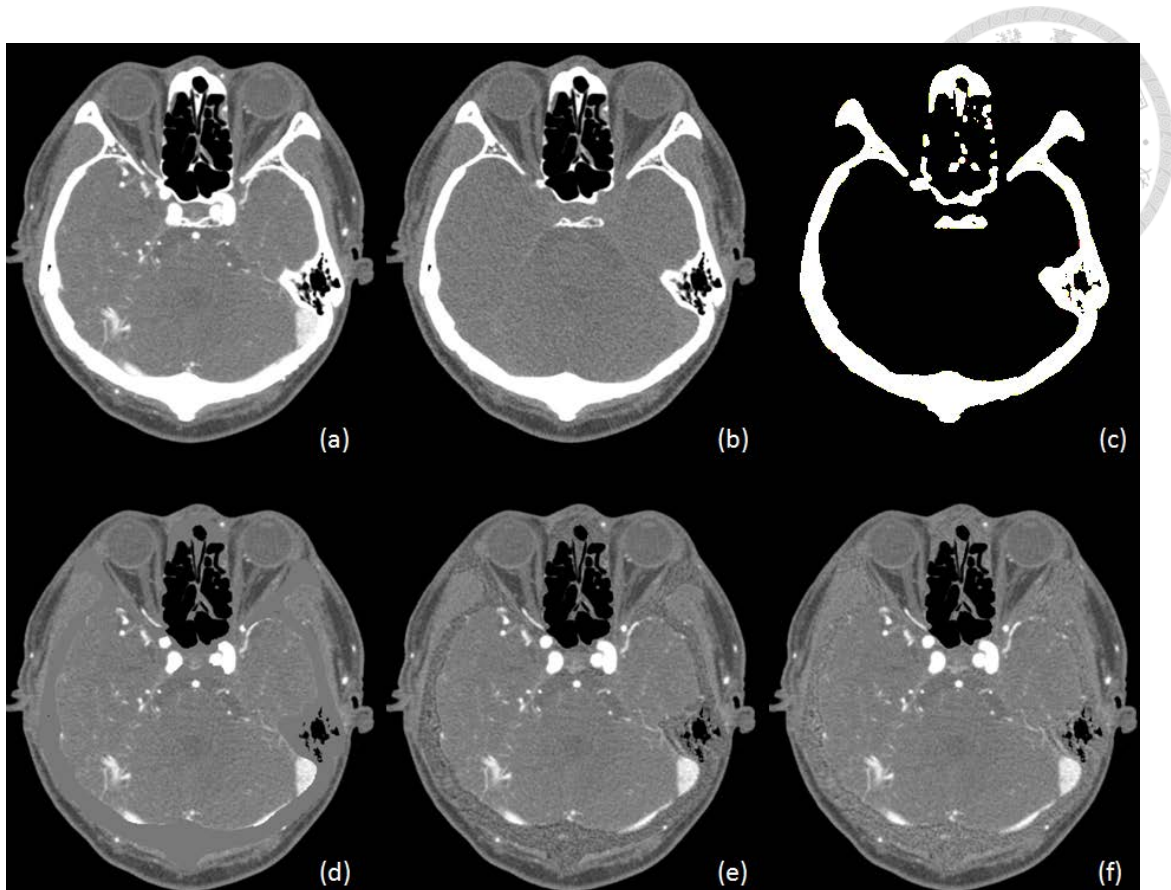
Generation of hybrid bone subtraction CTA after registration. (a) Postcontrast image (CTA). (b) Precontrast image. (c) Bone mask generated from precontrast image by threshold ($>150\text{HU}$) and 1-pixel dilatation. (d) MMBE image from CTA with soft tissue value (40HU) in bone mask. (e) Hybrid bone subtraction CTA with simple subtraction in the mask, resulting in lower density in the bone. (f) Hybrid bone subtraction CTA with soft tissue compensation to achieve an even background.
